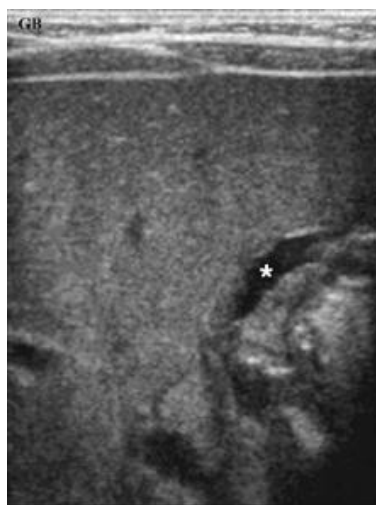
Abdominal ultrasound demonstrates a contracted gallbladder (white star - GB)
